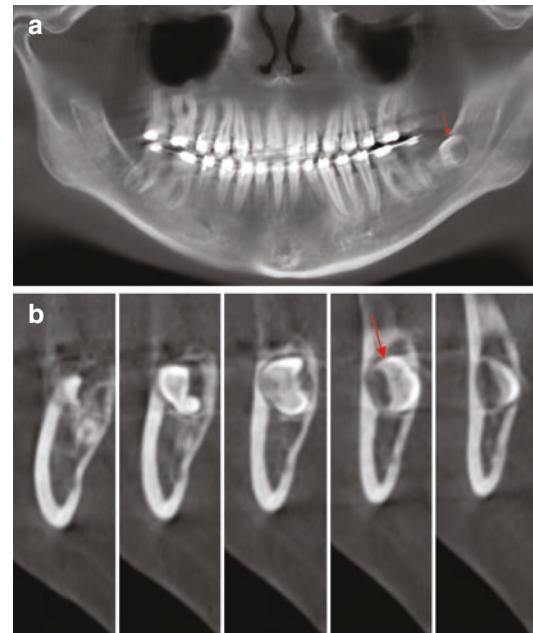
Reconstructed panoramic image (a) and cross-sectional images (b) from CBCT data showing the relationships of the forming tooth with the surrounding structures
